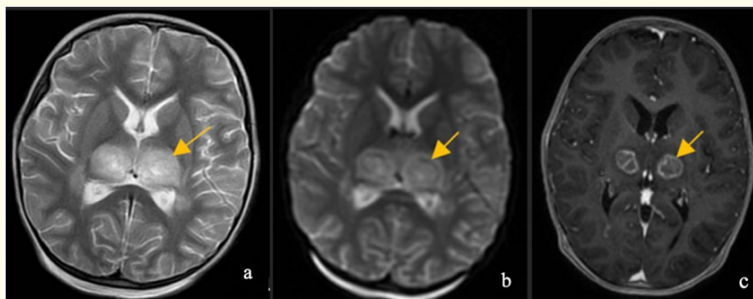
MRI in axial sections in T2 (a), diffusion (b) and T1 3D C+ (c) sequences shows bilateral thalamic lesions (yellow arrow) described in hypersignal in T2 sequences, presenting a restriction in diffusion and describing the trilaminar appearance (b) and a peripheral enhancement after injection of gadolinium (c).
